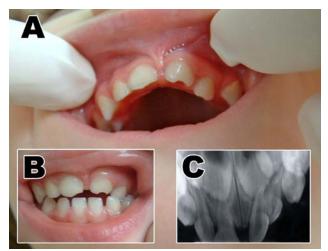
Palatal (A) and facial (B) view of teeth, revealing extent of trauma. C. Radiograph of the traumatized teeth.
